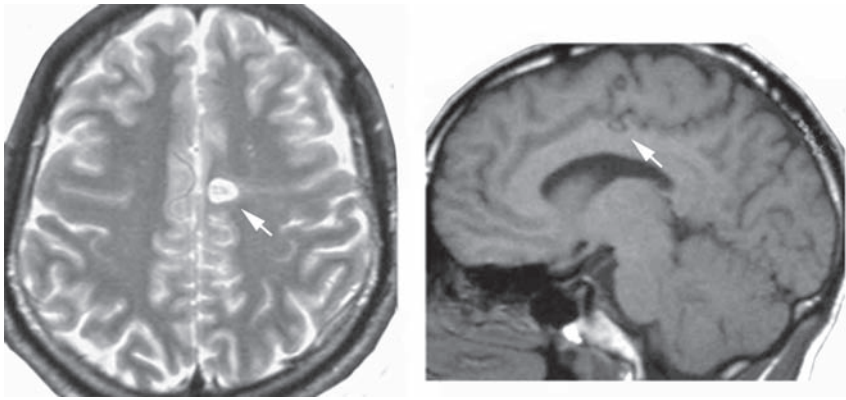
Post-operative magnetic resonance imaging showing signal changes at the location of the stereotactic radiofrequency lesions performed 6 months before. Left: parasagittal view of the left hemisphere, T1 signal. Right: Horizontal view, T2 signal. Used with generous permission from P. Kahane (Chassagnon et al., 2003).
